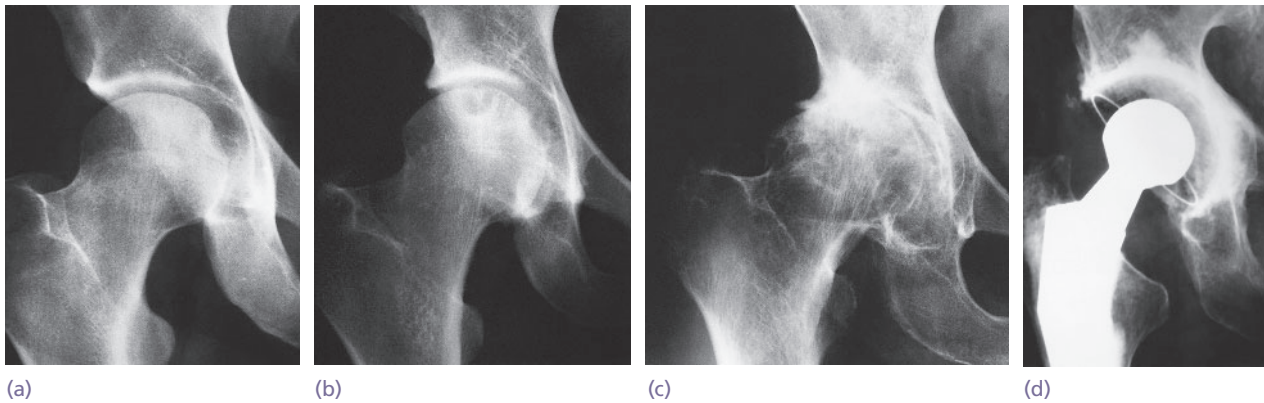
Plain X-rays of the hip Stages in the development of osteoarthritis (OA). (a) Normal hip: anatomical shape and position, with joint 'space' (articular cartilage) fully preserved. (b) Early OA, showing joint space slightly decreased and a subarticular cyst in the femoral head. (c) Advanced OA: joint space markedly decreased; osteophytes at the joint margin. (d) Hip replacement: the cup is radiolucent but its position is shown by a circumferential wire marker. Note the differing image 'densities': (1) the metal femoral implant; (2) the polyethylene cup (radiolucent); (3) acrylic cement impacted into the adjacent bone.
